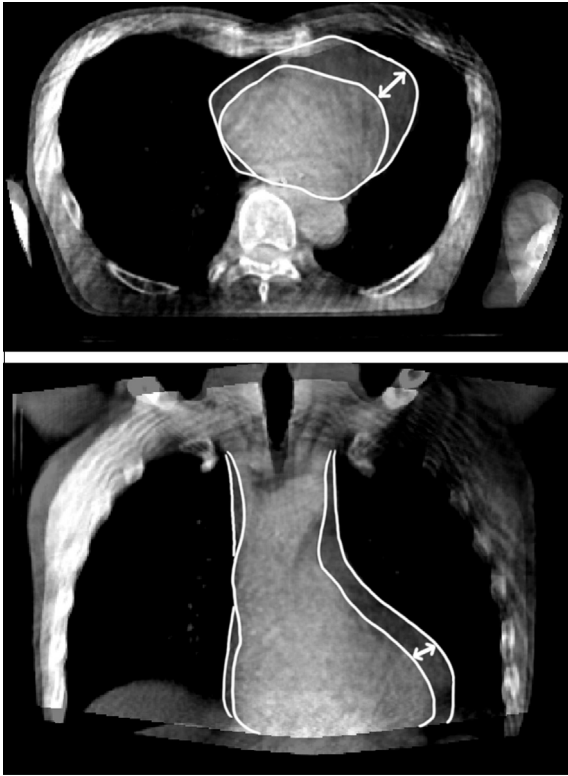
Overlay of planning CT (outer contour) and final CBCT (inner contour). Images are matched on bony anatomy. The heart contour is clearly larger on the planning CT scan in both views.
